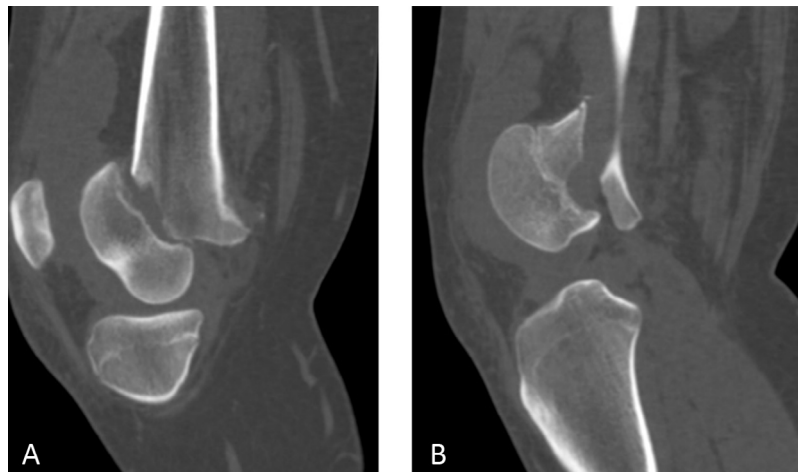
Computed tomography (CT) of right lower extremity on the day of initial trauma, showing (A) fracture through the physis of the right femur. (B) Sagittal reconstruction obtained at the same level of the fracture in a more lateral location, showing unfused physis, indicating skeletal immaturity at time of trauma
